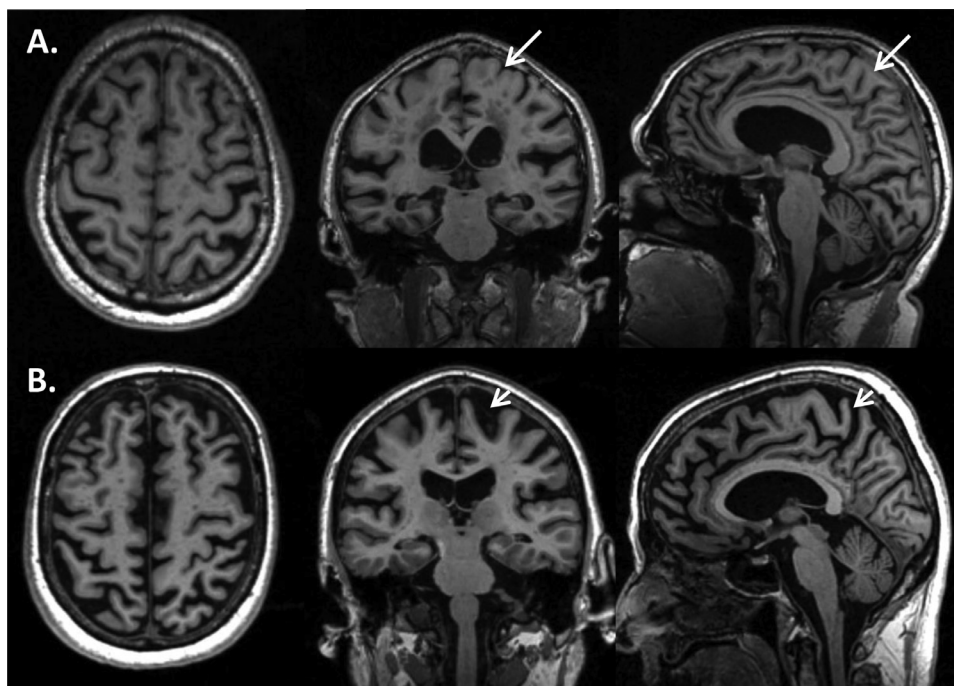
Examples of participants with positive and negative DESH scores. (A.) Participant identified as having DESH-like MRI features by the automated algorithm with a positive DESH score of 3.2. Relative narrow sulci at the vertex is shown by the arrows. (B.) Participant with a negative DESH score of -3.0, indicating absence of DESH features. Diffuse sulcal widening is indicative of atrophy (arrow heads).
